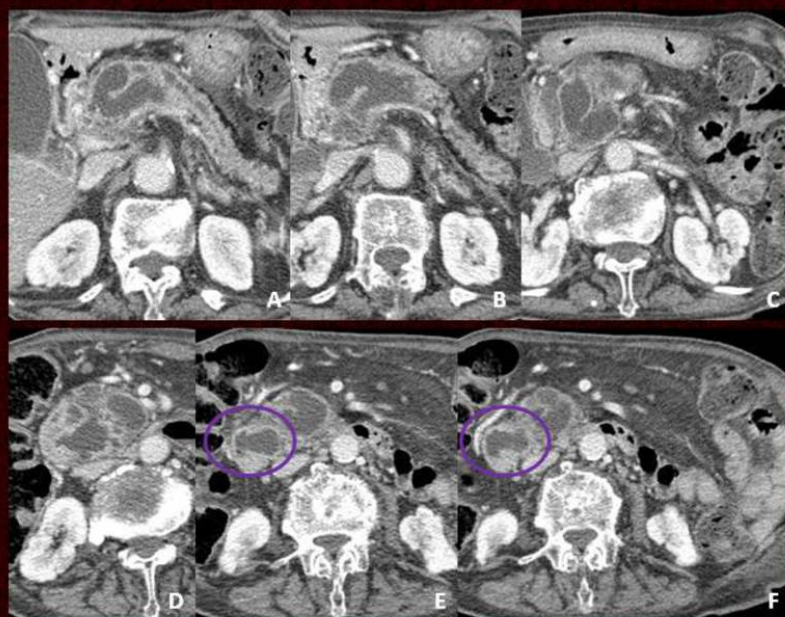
Main duct IPMT. CT scan shows marked diffuse dilatation of the main pancreatic duct with some distal parenchymal atrophy. A bulging papilla is also identified, as a result of obstructing mucus (circles in E and F).
